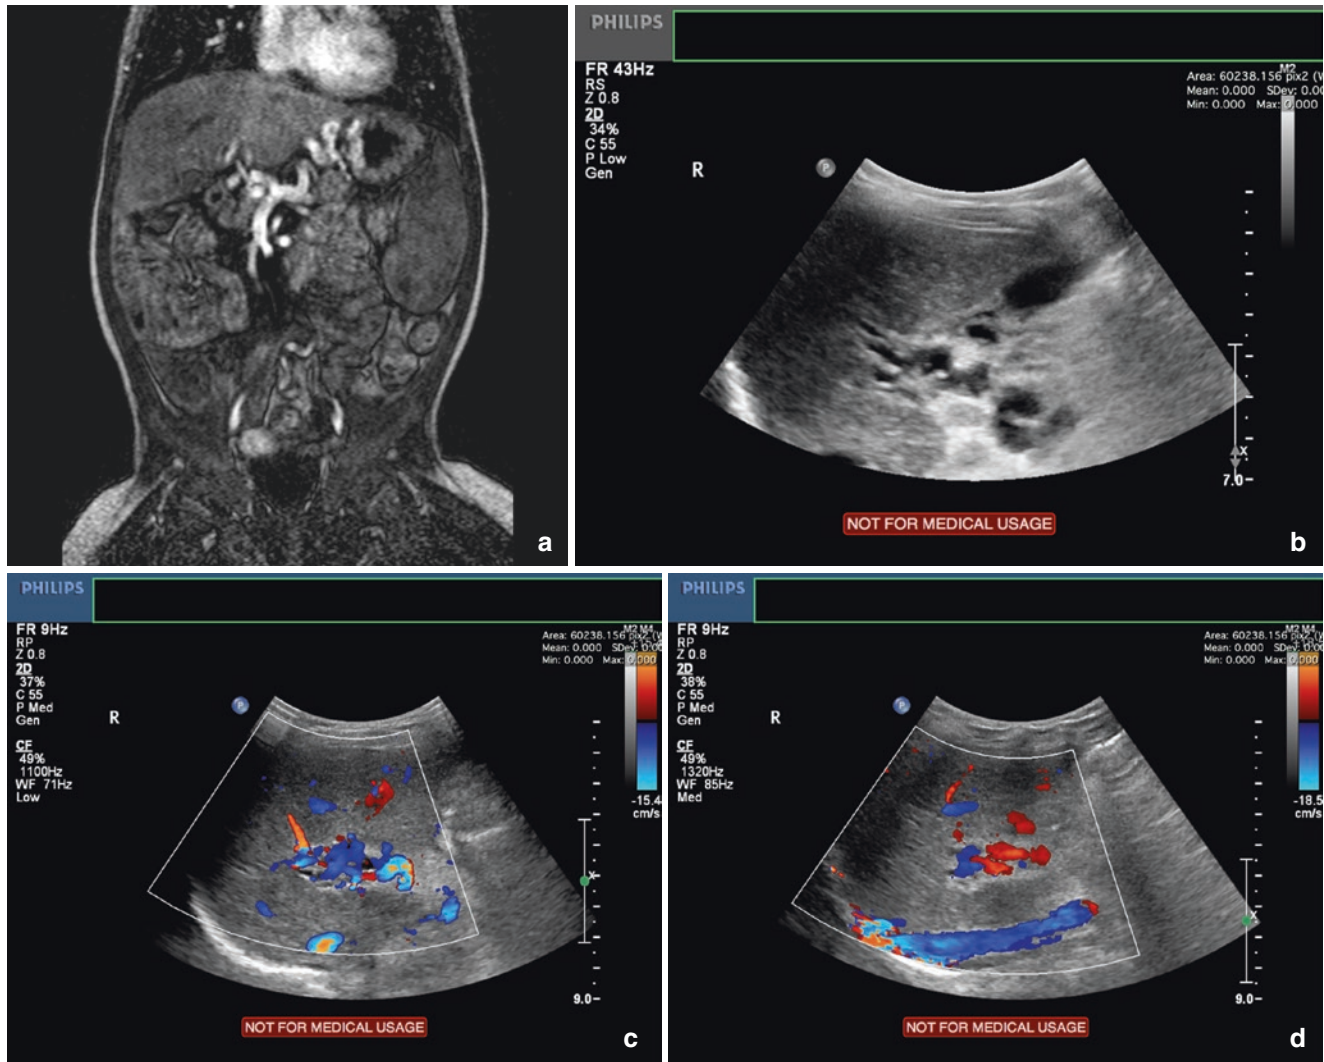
(a) Portal hypertension-MRI showing dilated portal vessels and an enlarged spleen. (b) Ultrasound of portal hypertension showing dilated portal vessels. (c) Ultrasound of portal hypertension. Doppler
